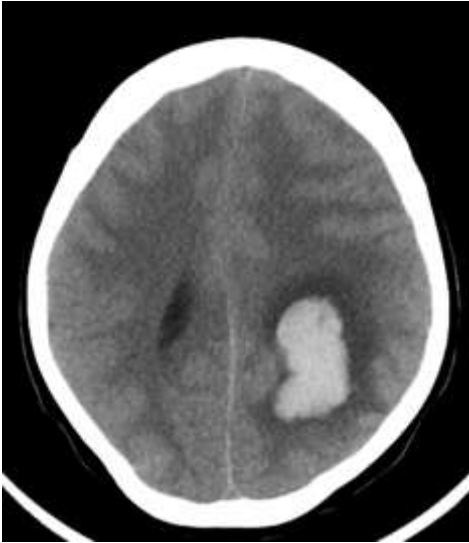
CT brain left parietal 2 hemorrhagic lesions with surrounding edema causing effacing the left lateral ventricle
